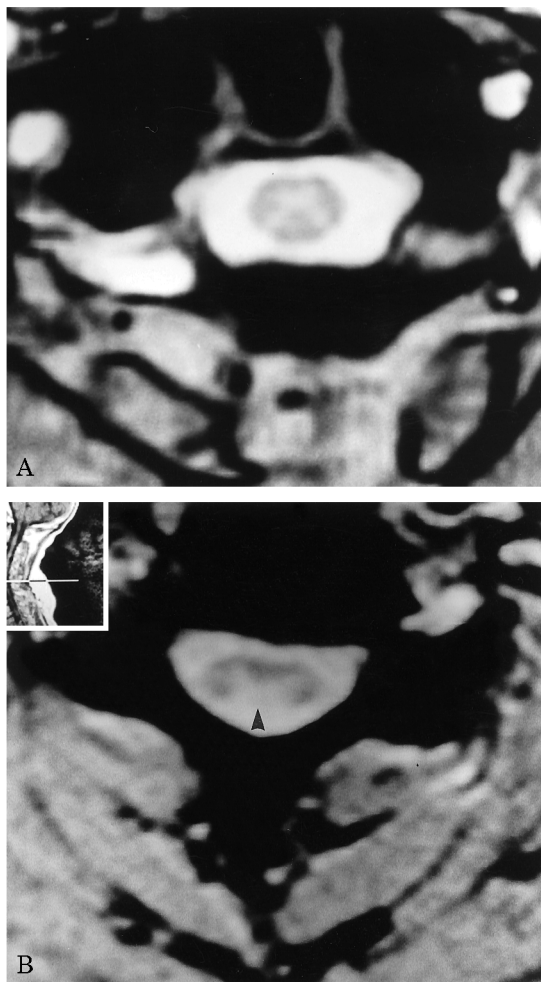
Axial T2-weighted gradient echo magnetic resonance imaging scans (repetition time, 500 msec; echo time, 9 msec; flip angle, 20°) of cervical spinal cord (C4 level) (A) Normal appearance of posterior column white matter and of anterior and posterior horns. (B) Arrow shows diffuse high signal intensity in the posterior columns (Patient 1).
